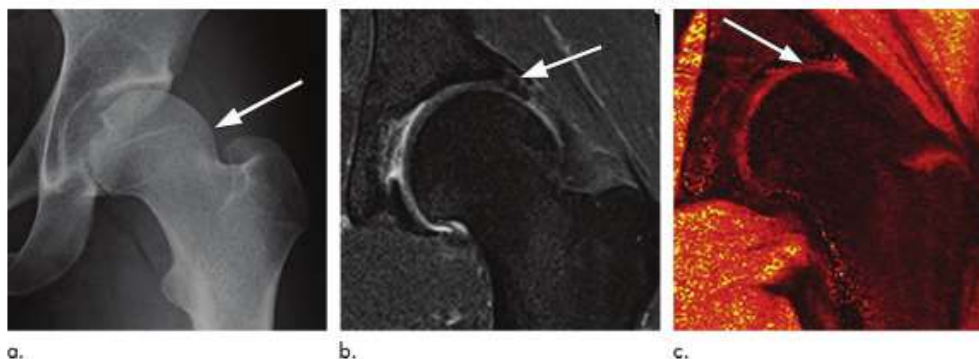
Delayed gadolinium-enhanced MRI of cartilage (dGEMRIC) of the left hip joint of a 22-year-old female gymnast with clinical symptoms of femoroacetabular impingement (Roemer et al, 2022).
